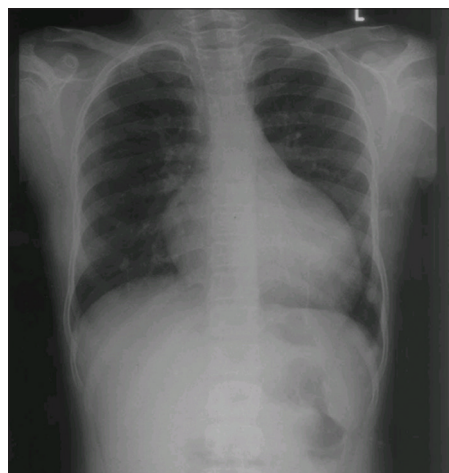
Posteroanterior chest radiograph showing cardiomegaly
